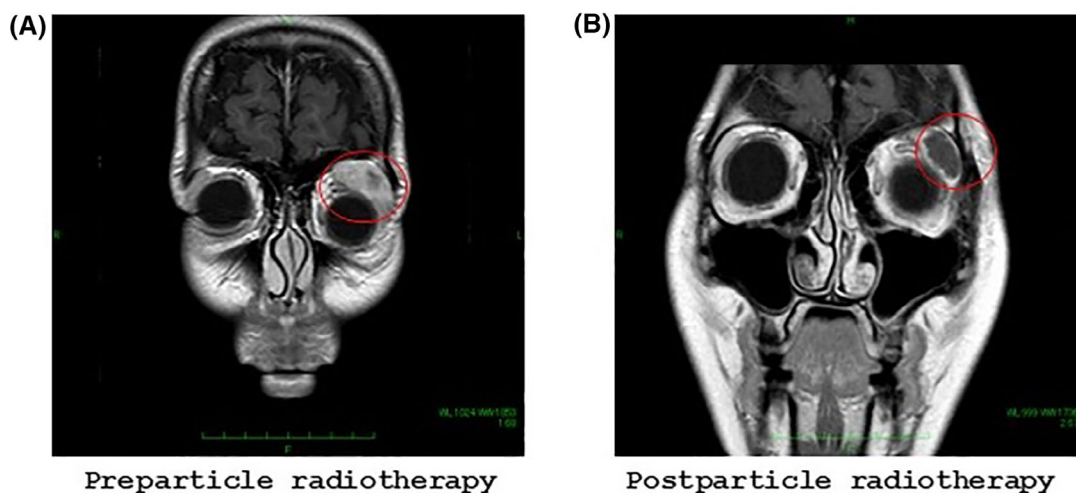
(A) Coronal magnetic resonance imaging view of preparticle radiotherapy with left lacrimal gland tumor. (B) Coronal magnetic resonance imaging view of postparticle radiotherapy with left lacrimal gland tumor
